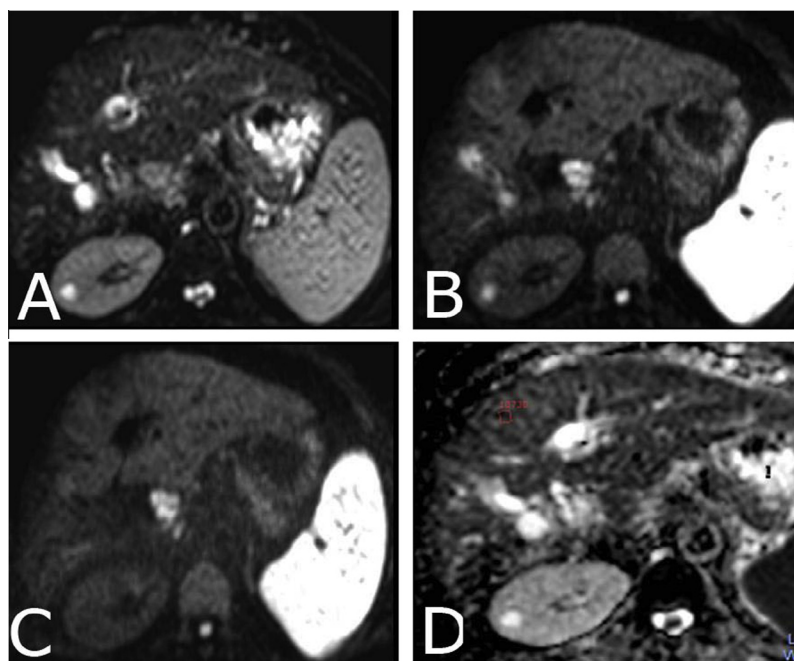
Diffusion weighted MR images of 55 year old male patient with small HCC, DWI at b_0 (A), DWI at b_500 (B), DWI at b_{1000} (C) and ADC map (D) shows isointense SI with restricted diffusion with mean ADC value at $b_{1000} = 0.9 \times 10^{-3} \text{ mm}^2/\text{s}$.
